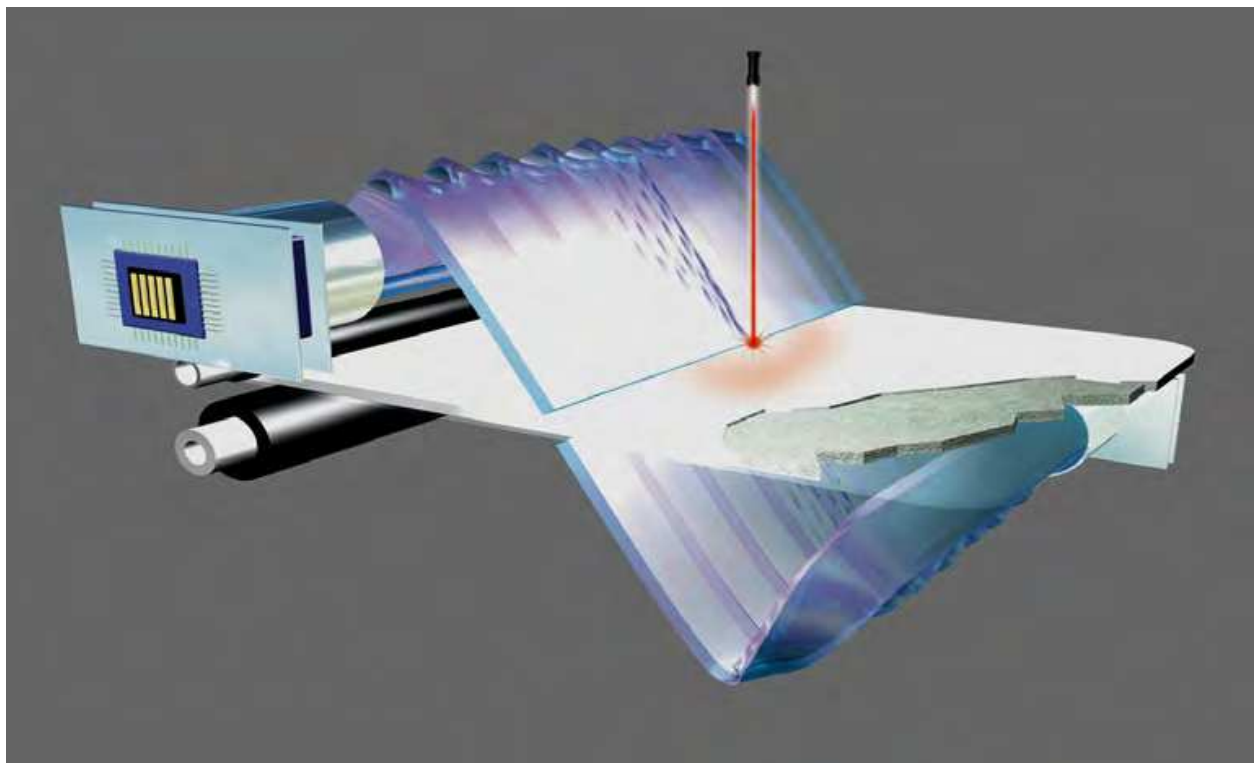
CR mammography dual optical collection system scanned with a red laser beam. (Courtesy of Fujifilm Medical, Stamford, CT)
